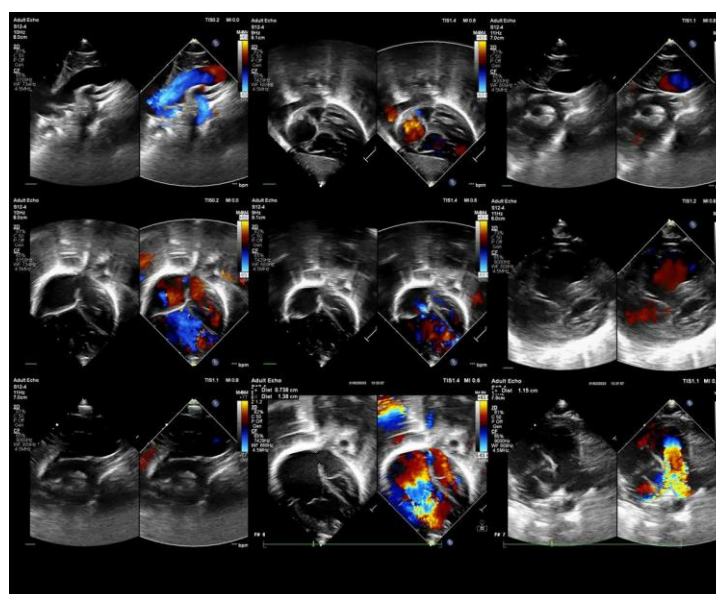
Results echocardiography in infant NMS, Age 2 month with Supracardiac (TAPVR)
